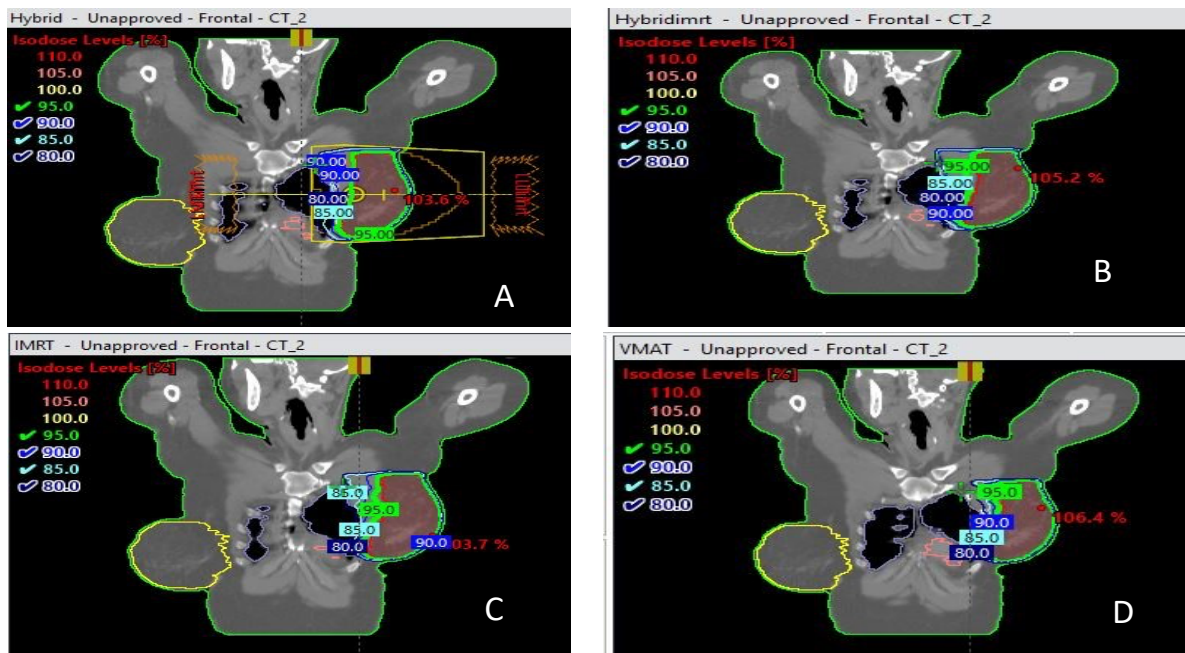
Coronal CT images with contoured structures and dose distribution for the four techniques; A. Hybrid (2 beams), B. Hybrid (5 Beams), C. IMRT, and D. VMAT.
